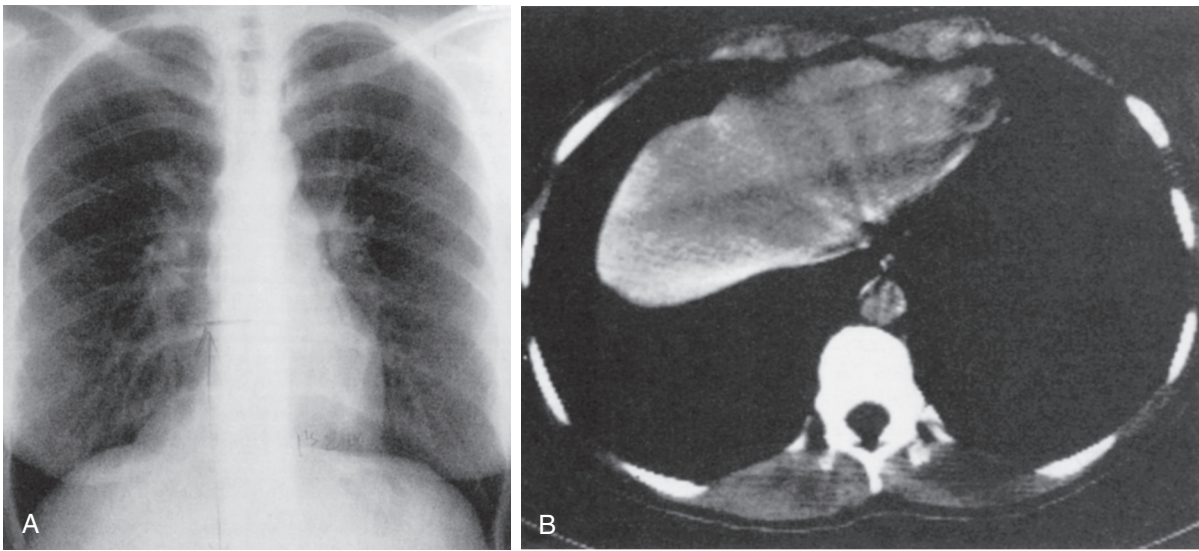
■ A, Chest film of a pericardial cyst in the right pericardiophrenic angle. B, CT image shows the characteristic nearer attenuation of the mass and the typical anatomic location.
